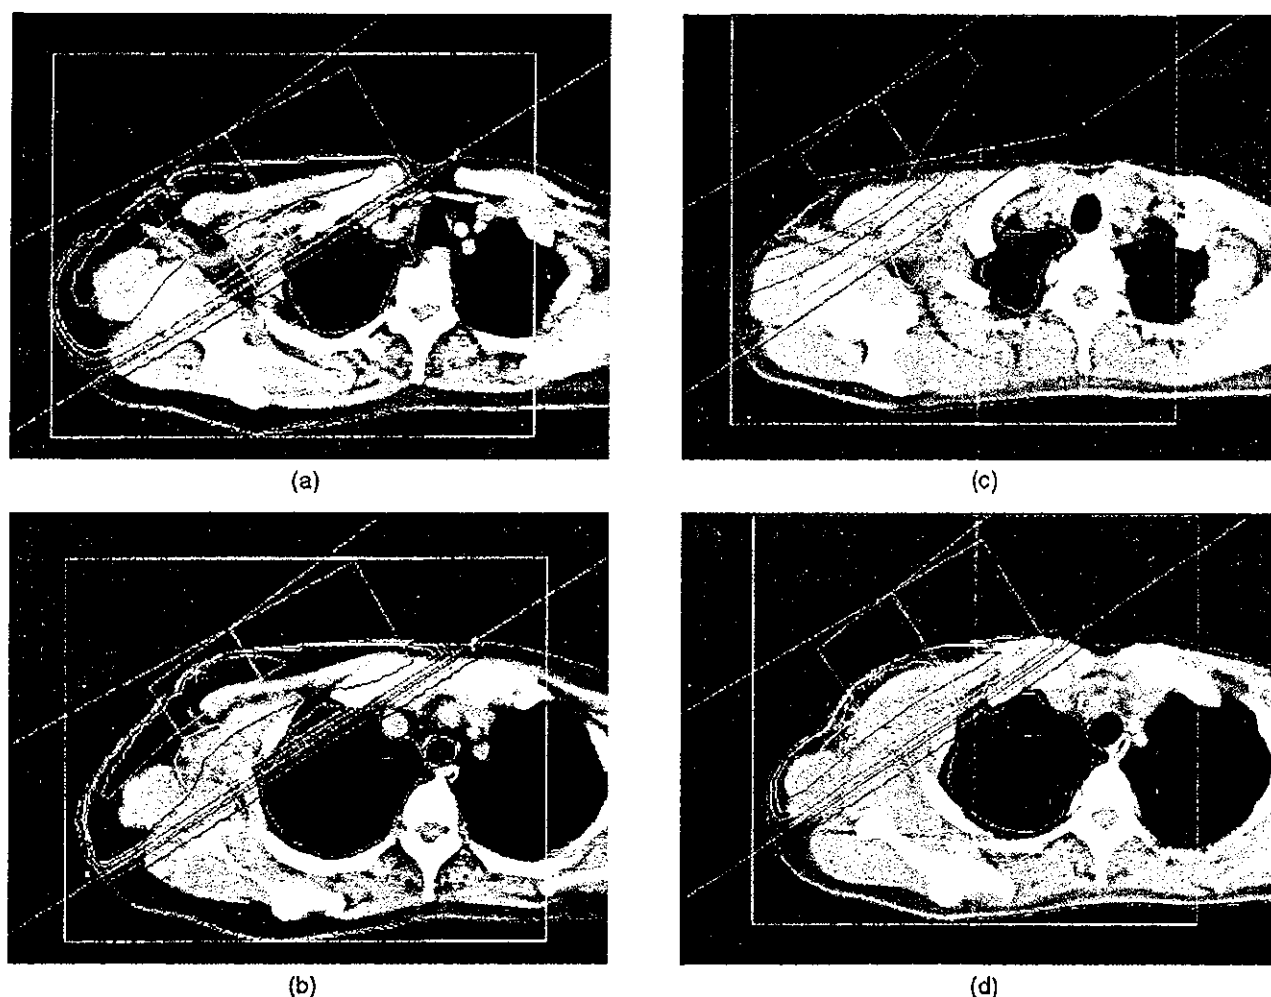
Dose-distribution curve on CT slices: levels just below humeral head and axilla of patient treated with (a,b) MTIT and (c,d) CTIT. Surgical clips, seen in axillary region, were left as axillary dissection markers. White lines show limits of Levels I, II, and III. Green line is 100% isocenter dose line, blue 90%, yellow 80%, and so on.
